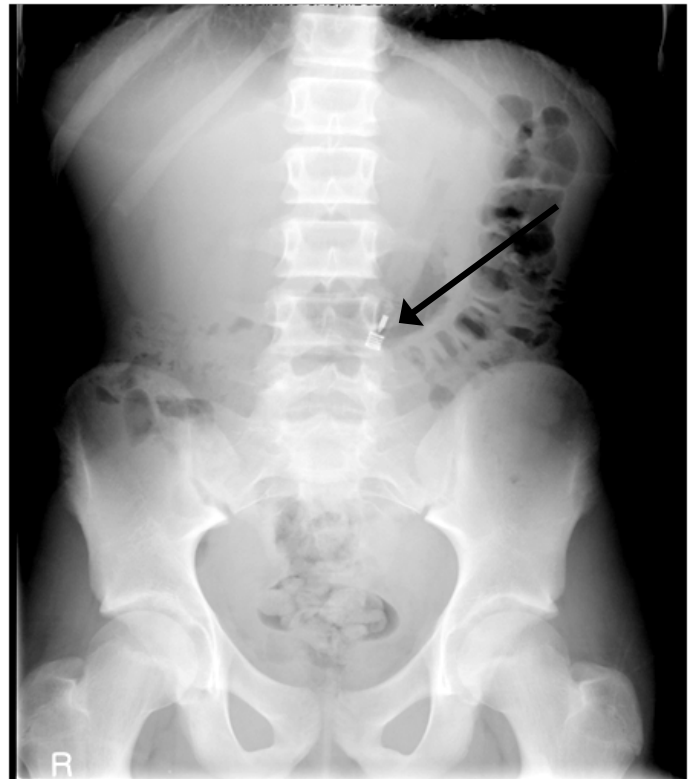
A retained pen in the stomach. There was no change in the position of the foreign body on a chest radiograph, 10 days after accidental ingestion.
